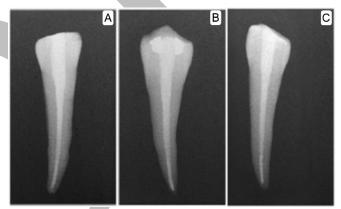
Periapical X-ray films showing a bucco-lingual view of teeth obturated with: A) E&Q plus obturation.B) Thermafil obturation. C) Lateral condensation technique.
